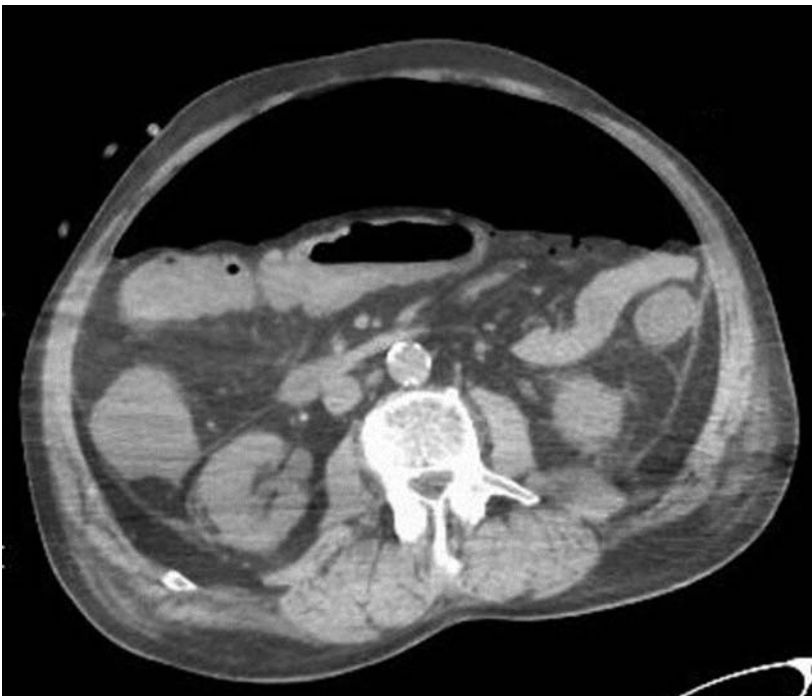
Abdominal computed tomography scan in case 2 showing massive pneumoperitoneum.
